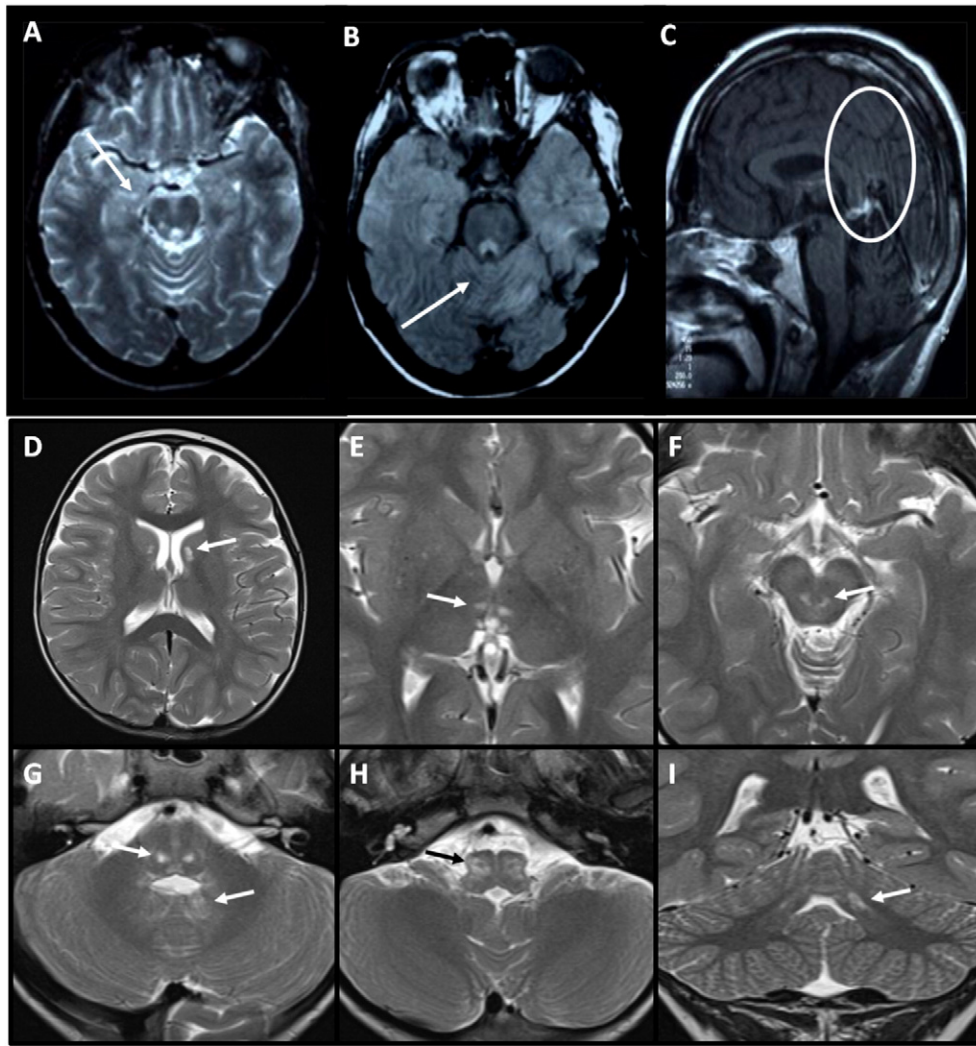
Radiological features of patient 1: axial T2-weighted images (T2WI) (A–C) showing (A) hyperintense lesion (arrow) in the head of the left caudate nucleus; (B) symmetrical involvement of the midbrain tegmentum (arrow); (C) involvement of periaqueductal gray matter (circle). Radiological features of patient 2: Axial T2WI (D–I) showing bilateral hyperintense lesions (indicated by arrows) of the head of the caudate nuclei (D) and the thalamic posteromedial ventral nuclei (E). Symmetrical involvement of the dorsal midbrain (F), dorsal pons and deep cerebellar white matter (G) and olivary nuclei (H) is also noted. Coronal T2WI shows additional lesion of the left dentate nucleus.
